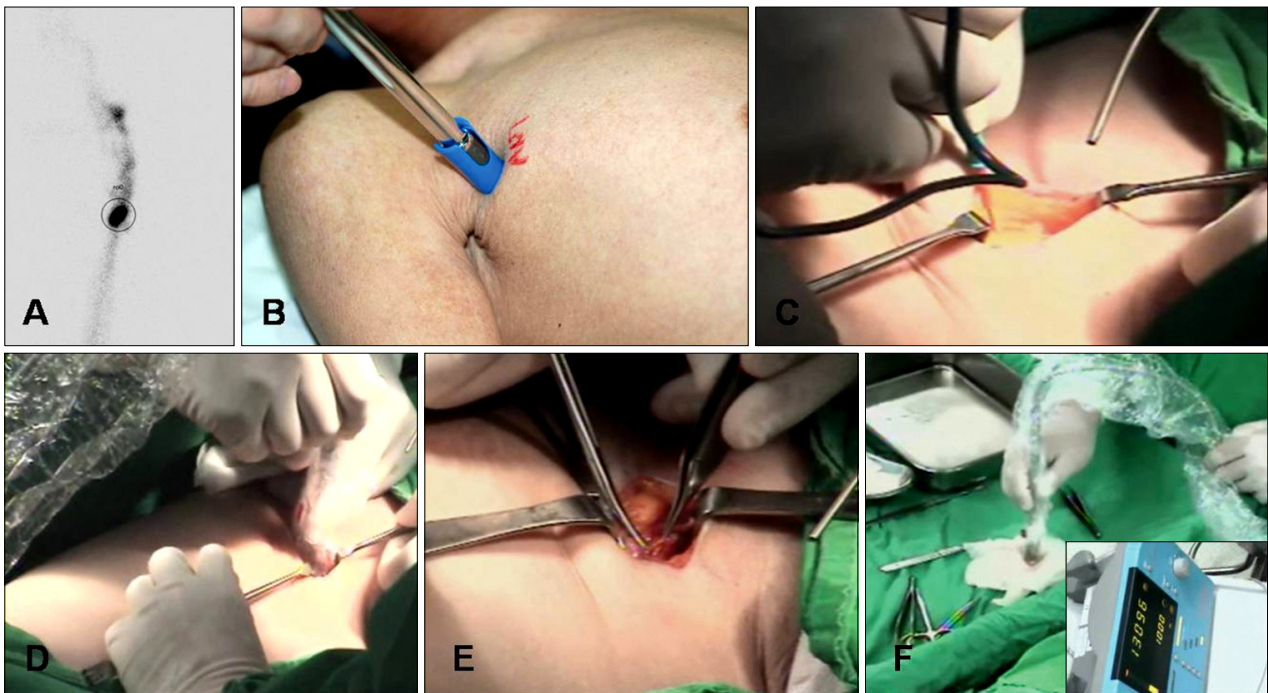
(A) The lymphoscintigram obtained from a patient who recently underwent surgery for cutaneous melanoma on the left sole: Lymph flows toward a single sentinel node in the left groin area (circle). (B) External γ -probe counting: approximation of the location of the SLN(s). (C) Incision (2~4 cm) on the skin & subcutis of the axilla. (D) Surgical dissection is guided by a hand-held γ detection probe and/or combined with blue dye in the axilla. (E) Harvesting SLN(s) & measuring their radioactivity. (F) Confirmation of no more significant radioactivity except the SLN(s). The excised SLN showed high radioactivity (inset).
